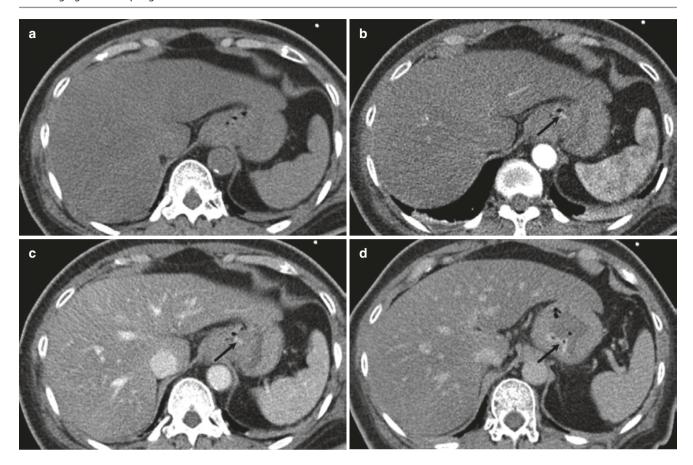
Mallory-Weiss syndrome. (a–c) Unenhanced, arterial phase, and venous phase CT images show extravasation of contrast at gastroesophageal junction (arrow). (d) Delayed image shows accumulation of extravasated contrast in gastric mucosal folds
